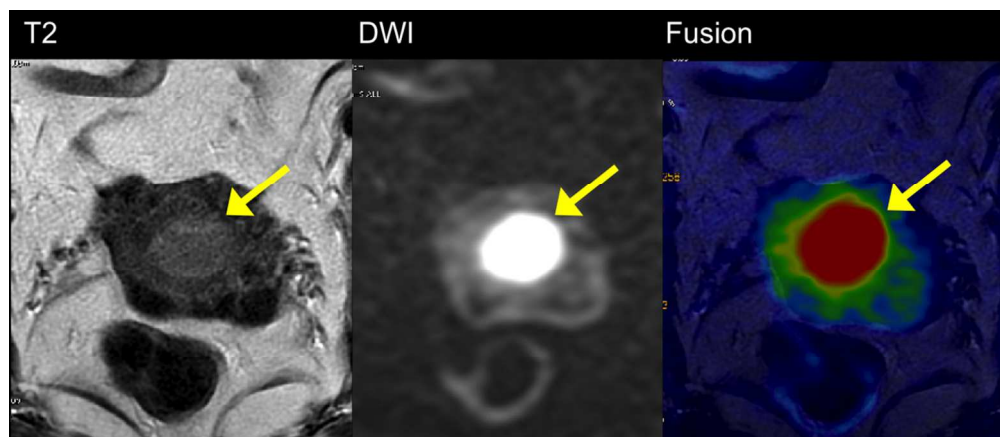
70 year-old female with endometrial carcinoma without myometrial infiltration (Stage IA). Comparison of axial oblique T2WI (a), DWI (b) and fused T2 and DWI (c). The contrast between the tumor and the myometrium is higher with DWI than with T2WI with better appreciation of the margins on the fused T2-DWI image.
